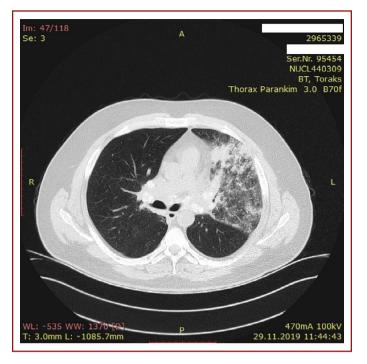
Silicosis in a 50-year-old stone crusher. Axial high-resolution computed tomography with lung window (W: 1500, C: –500) shows coalescing diffuse ground-glass opacities and interlobular septal thickenings on the left upper lobe.
